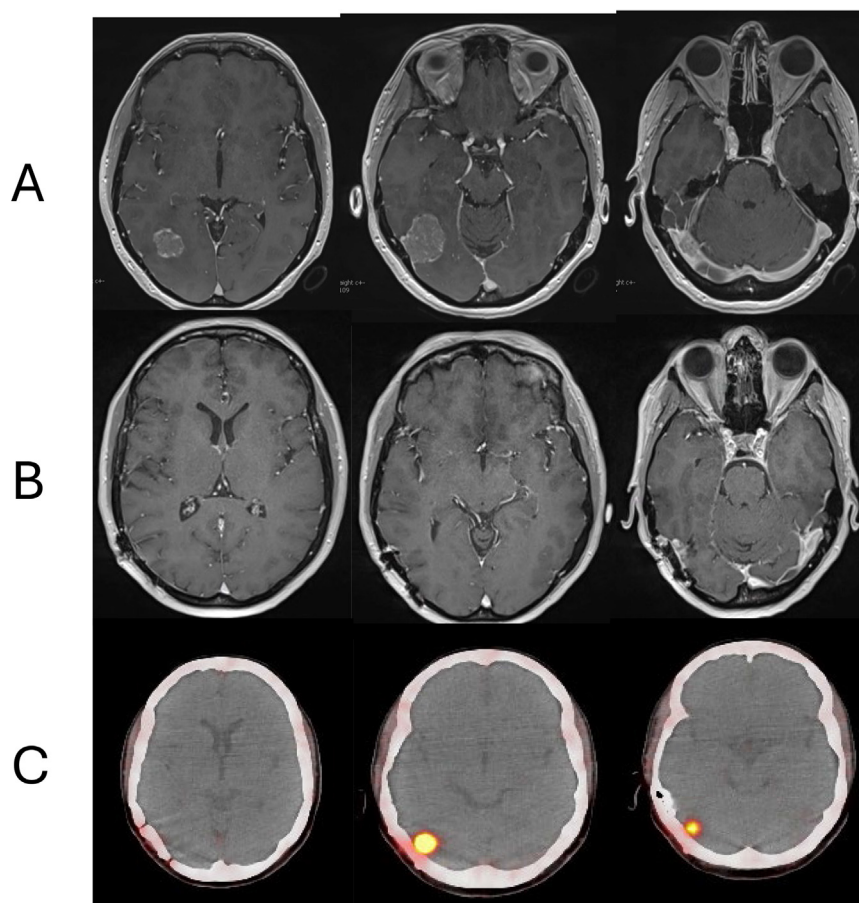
Case 2-Grade 2 meningioma with residual disease on PET. (A) Preoperative MRI. (B) Postoperative MRI. (C) Post-operative PET. *Abbreviations:* MRI = magnetic resonance imaging; PET = positron emission tomography.
